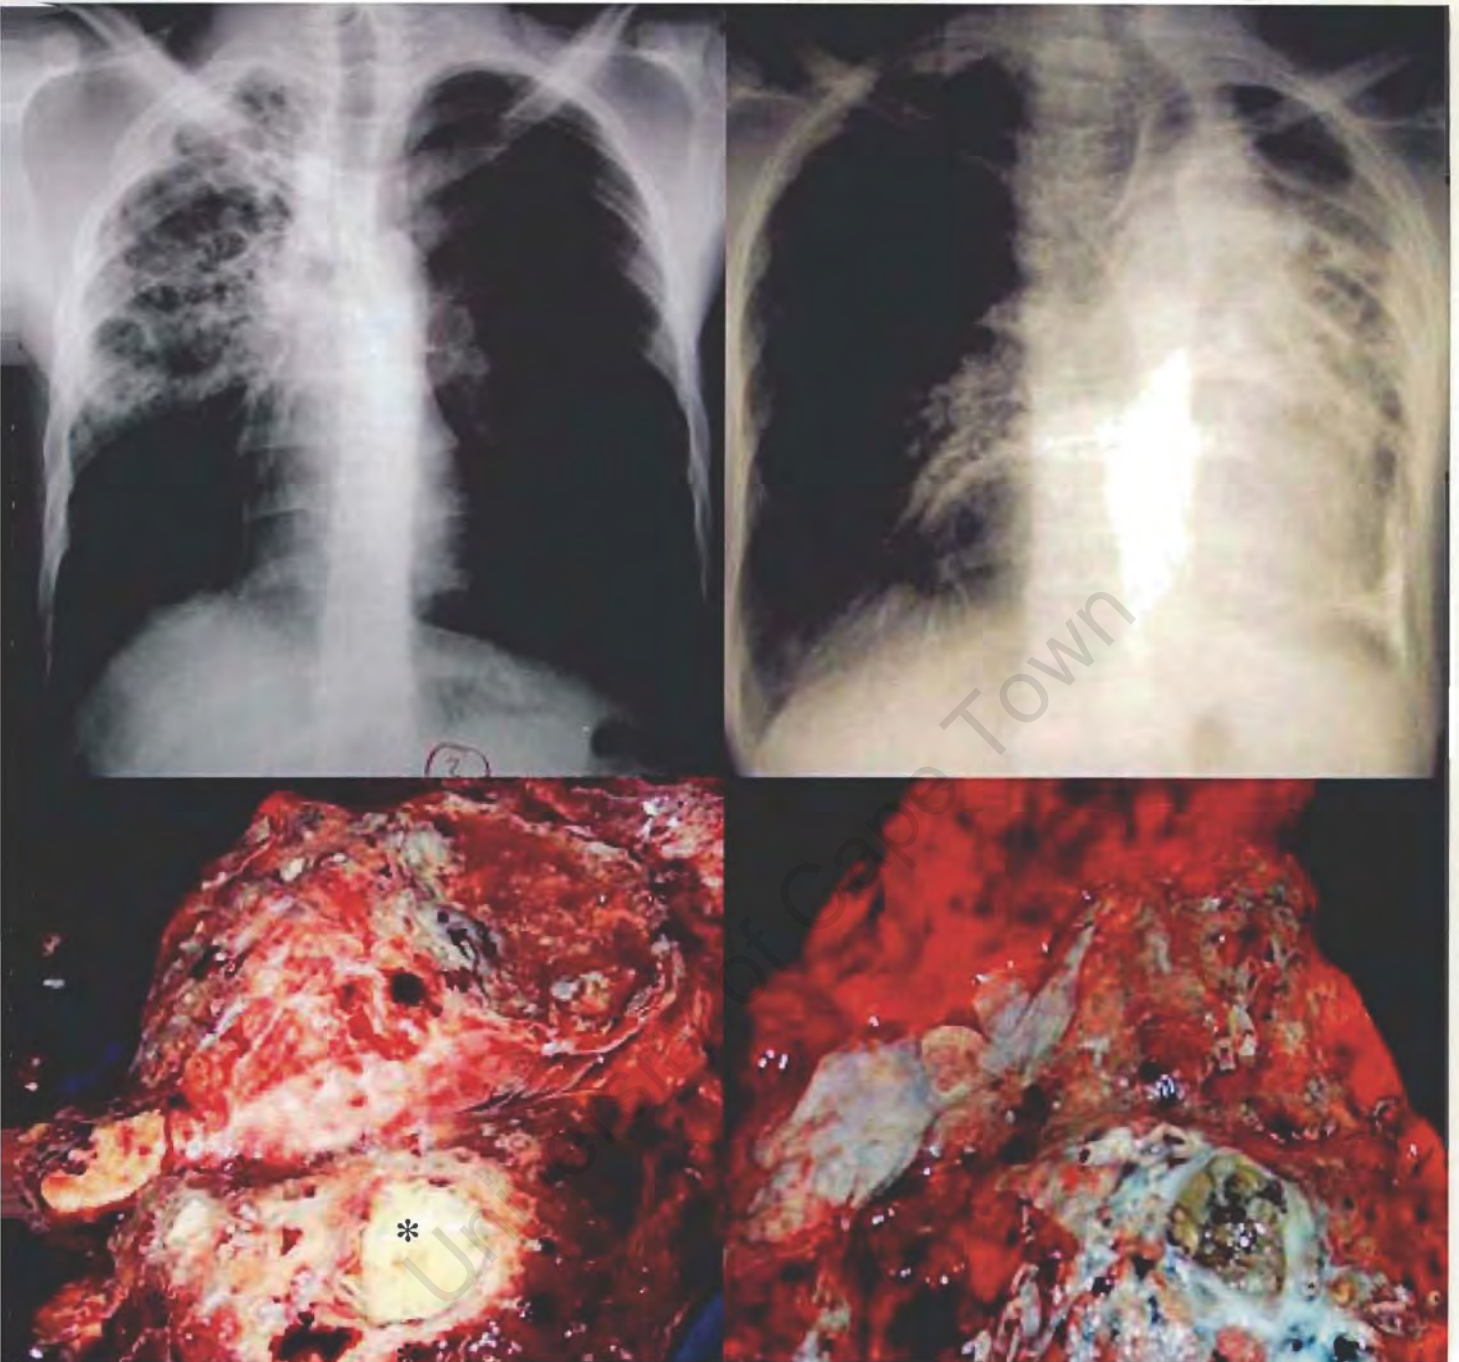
Pre-operative chest radiographs and resected lungs of patients #2 (left) and #5 (right). The resected lungs were almost entirely destroyed. Both lungs contained areas of cavitation, fibrosis, nodules and granulomas with central necrosis, but only the lungs of patients with active disease contained caseous necrosis (*).
